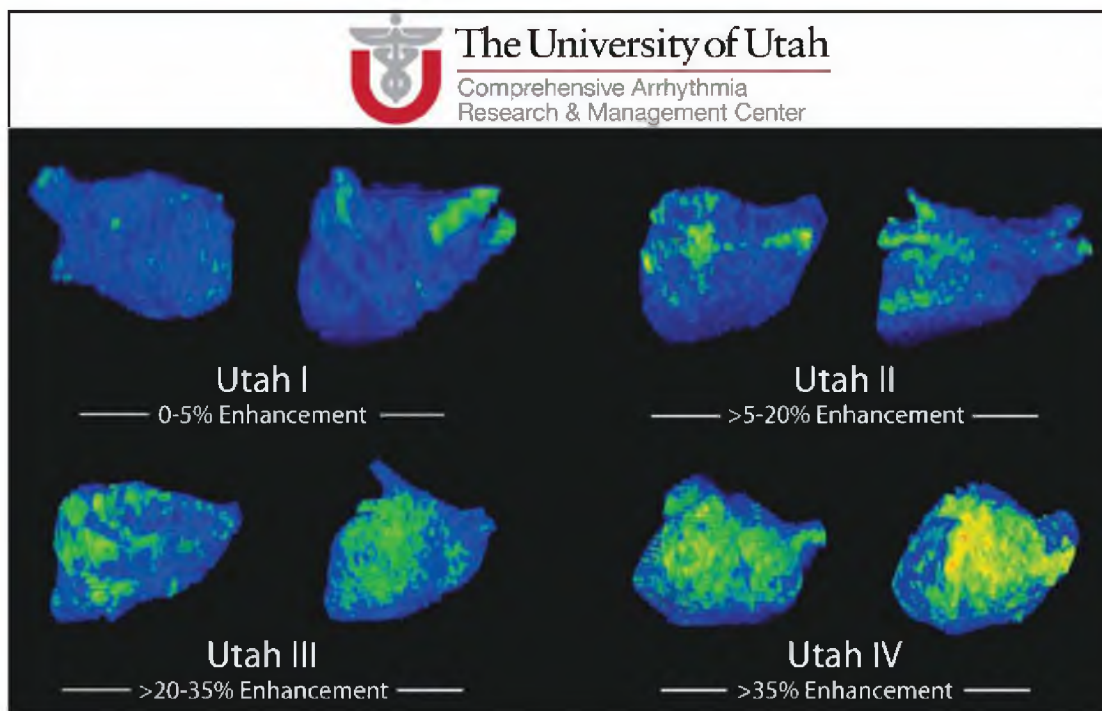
Utah staging system for stratifying the amount of preablation enhancement of the left atrial wall. Images in each of the four panels show examples of late gadolinium-enhanced magnetic resonance images, with enhanced regions color coded in green and normal tissues colored in blue.
